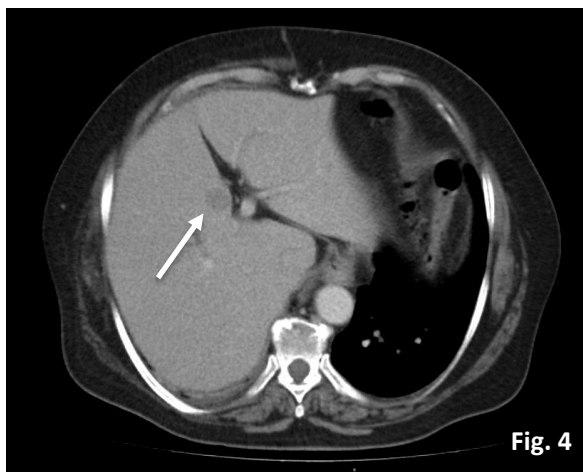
Chest CT Scan: metastatic lesions
